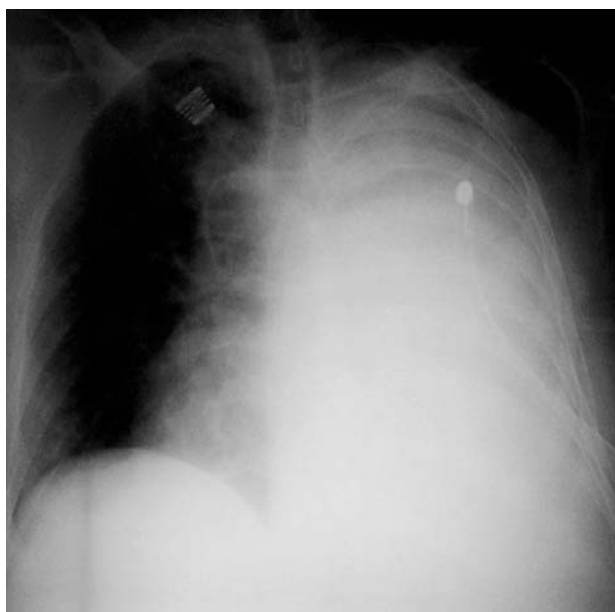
Chest x-ray of the patient with postsurgical chylothorax.
